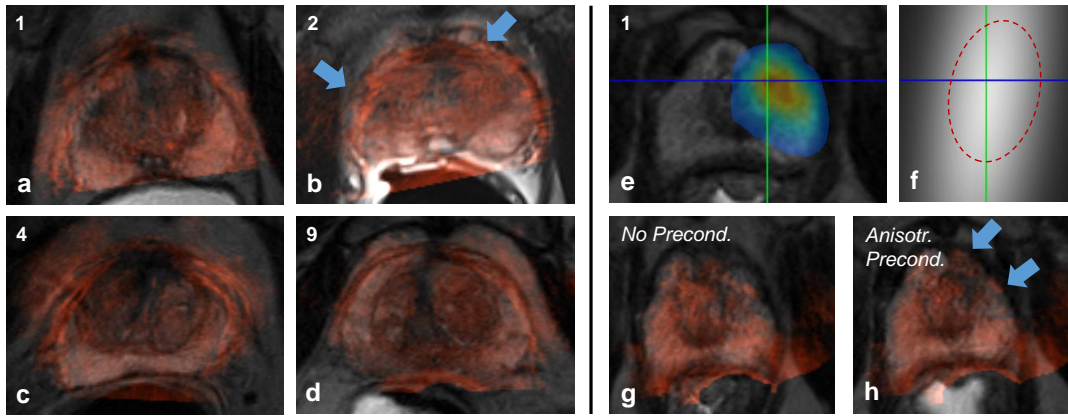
a-d) Registration result for four example datasets shown as axial slice overlays of the TRUS image (red) onto warped MR (greyscale). For Pat. 2, the registration converged to a local minimum (blue arrows). e) MRI with PET overlay for one patient in the apical region, with selection lesion t . f) Preconditioning weight map ζ_{aniso} , with estimated main directions of deformation (ellipse), allowing to improve registration without preconditioning (g) compared to the proposed anisotropic preconditioning (h, blue arrows). The patient numbers coincide with the ones in Tab. 2.4. Reprint from [255], ©2017 IEEE.
